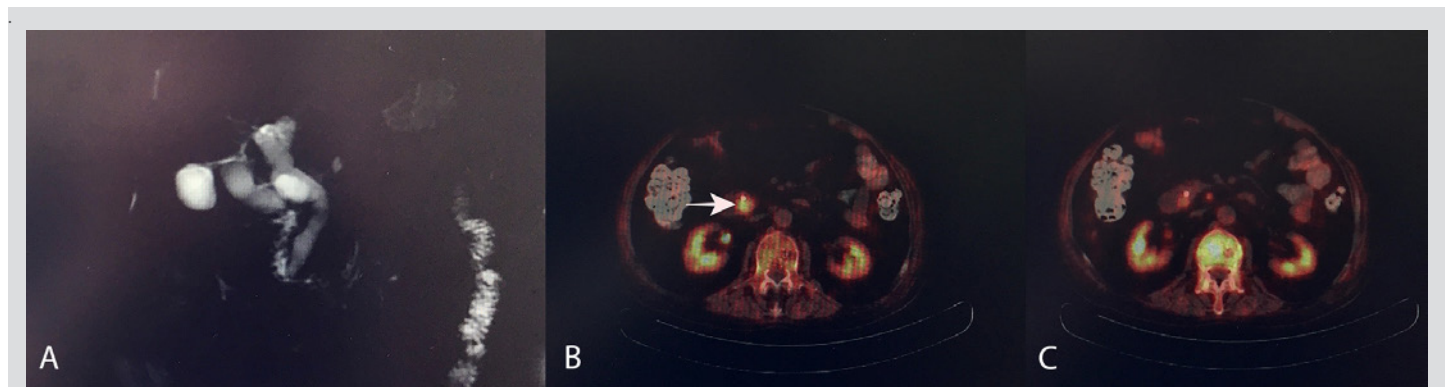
A. Magnetic resonance cholangiopancreatography showing bile duct dilation. B. PET-CT scan showing tracer uptake in the papilla tumour. C. PET-CT scan showing lumbar spinal metastasis
